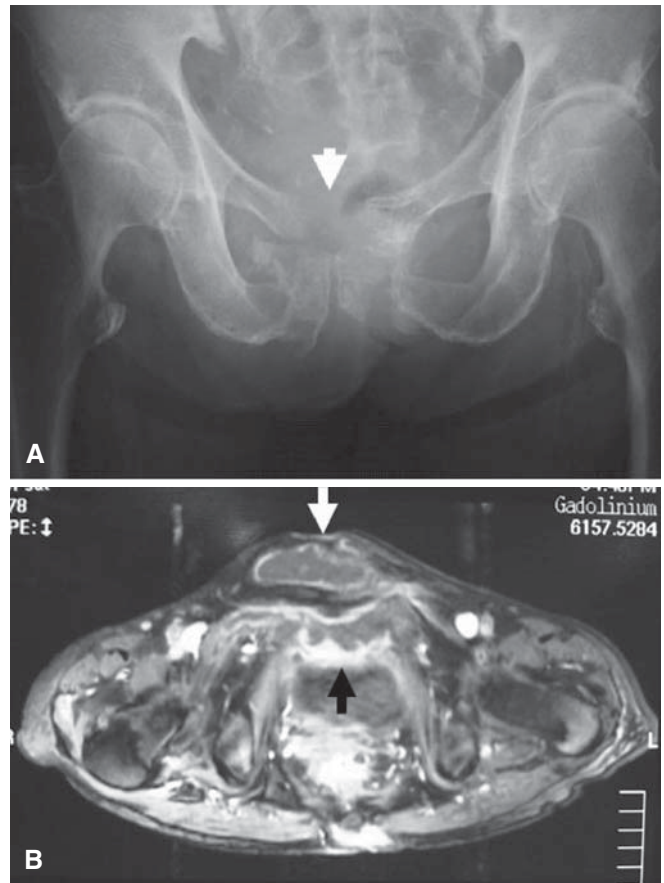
Case 1. A Plain anteroposterior pelvic radiography reveals a pelvic insufficiency fracture that occurred when the patient was 69 years old (*arrow*). B When the patient was 71 years old, she accidentally fell on the floor of her home. After the fall, pelvic ring disruption
